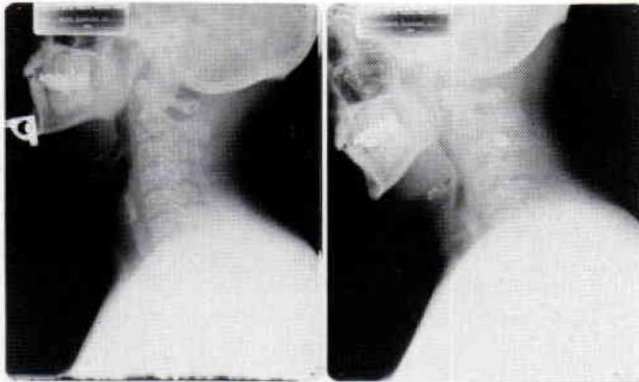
(left) Note improvement in x-ray of cervical spine with use of therapeutic pillow.
